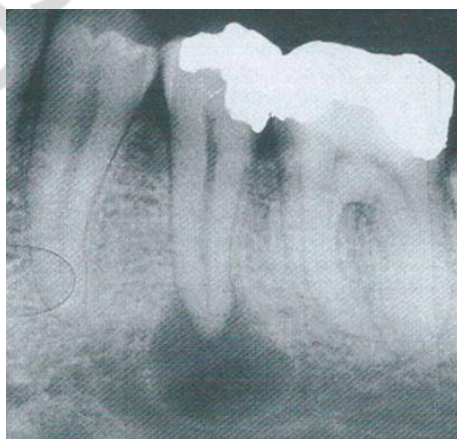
Radiograph of lower left second premolar demonstrating significant periapical pathology
